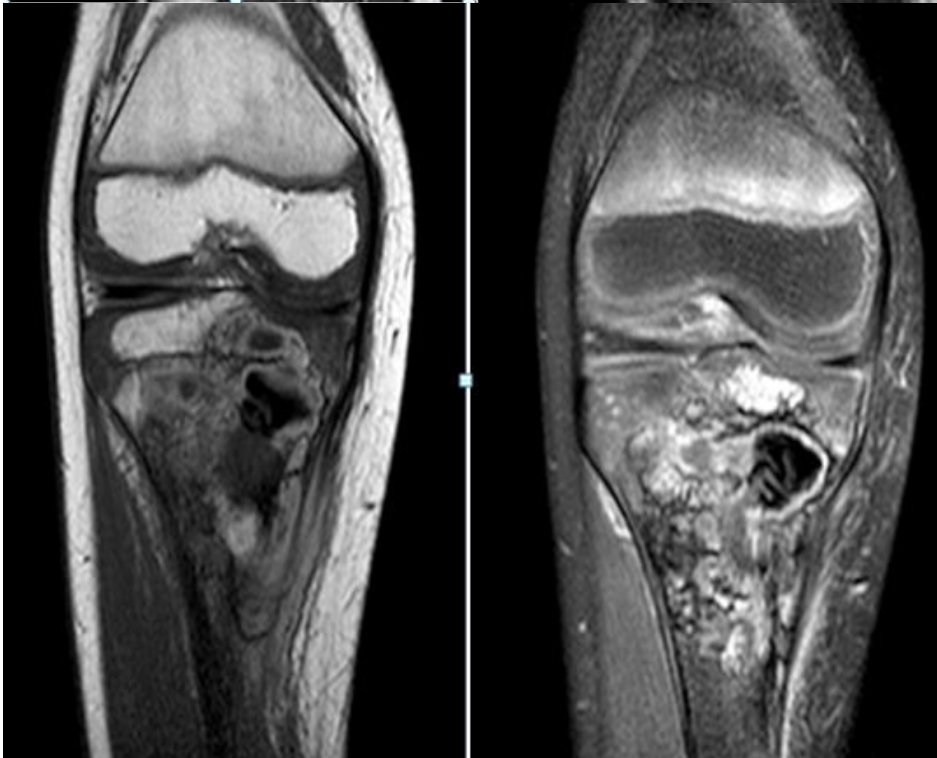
Coronal section, T1-weighted sequence (a: without injection / b after injection of Gadolinium): this lesion process is heterogeneously enhanced after injection of Gadolinium, it crosses the conjugation cartilage, extends towards the epiphysis; absence of skip metastasis or intra-articular extension
